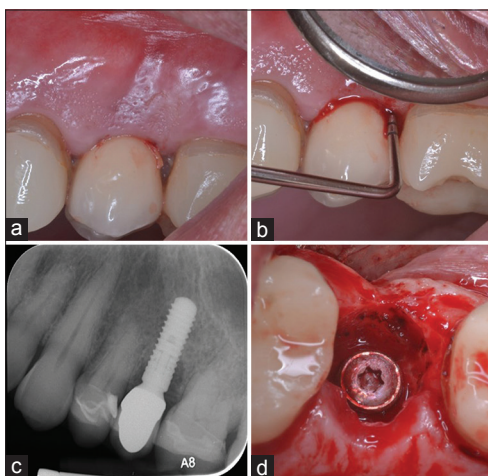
Diagnosis of peri-implantitis. (a) Bleeding on probing the peri-implant sulcus. (b) Probing depth of >4 mm. (c) Saucer shaped radiographic bone loss. (d) Osseous defect surrounding the implant upon flap opening
